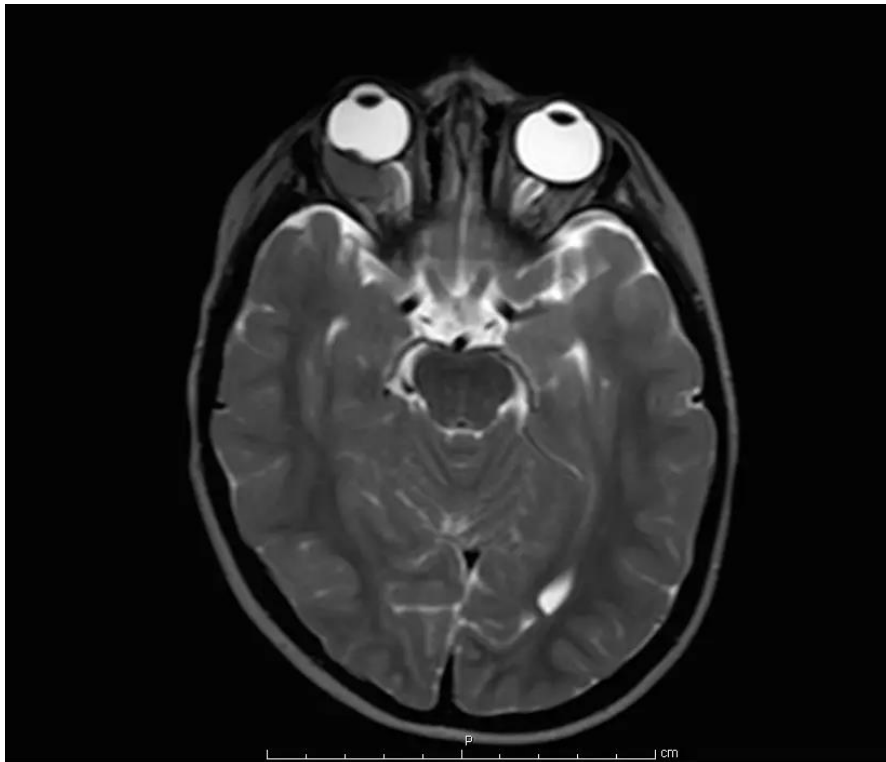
Magnetic resonance imaging (MRI) scan revealing a right-sided intraconal orbital mass that is hypointense compared to the vitreous. (3)
